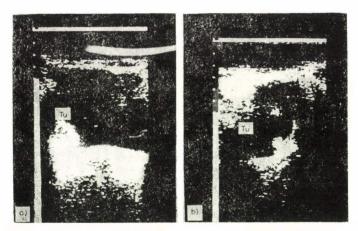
Ultrasonograms of a small nut-sized tumour on the right side of the bladder. a. transabdominal real-time transverse section; b. transabdominal real-time longitudinal section
